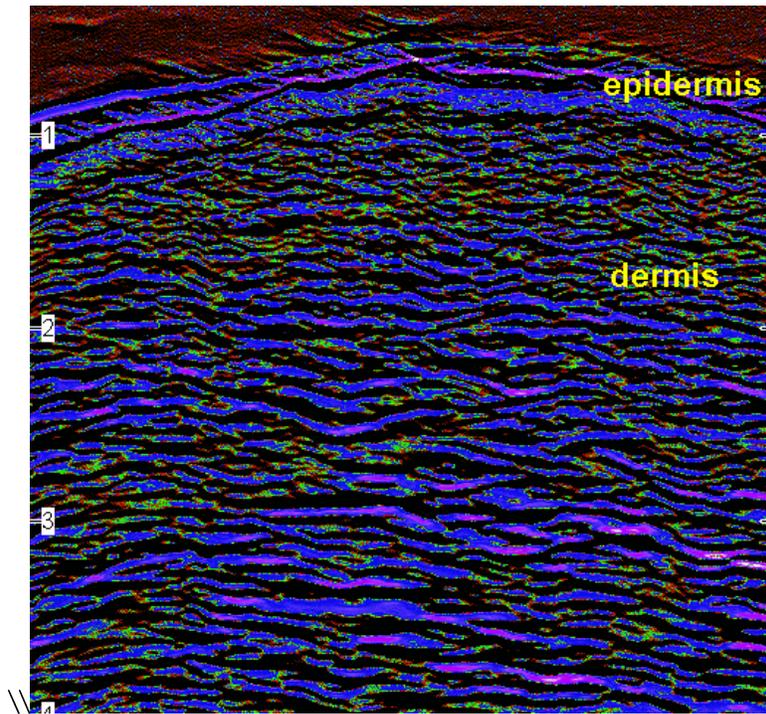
The ultrasound scan of one volunteer's normal skin.
